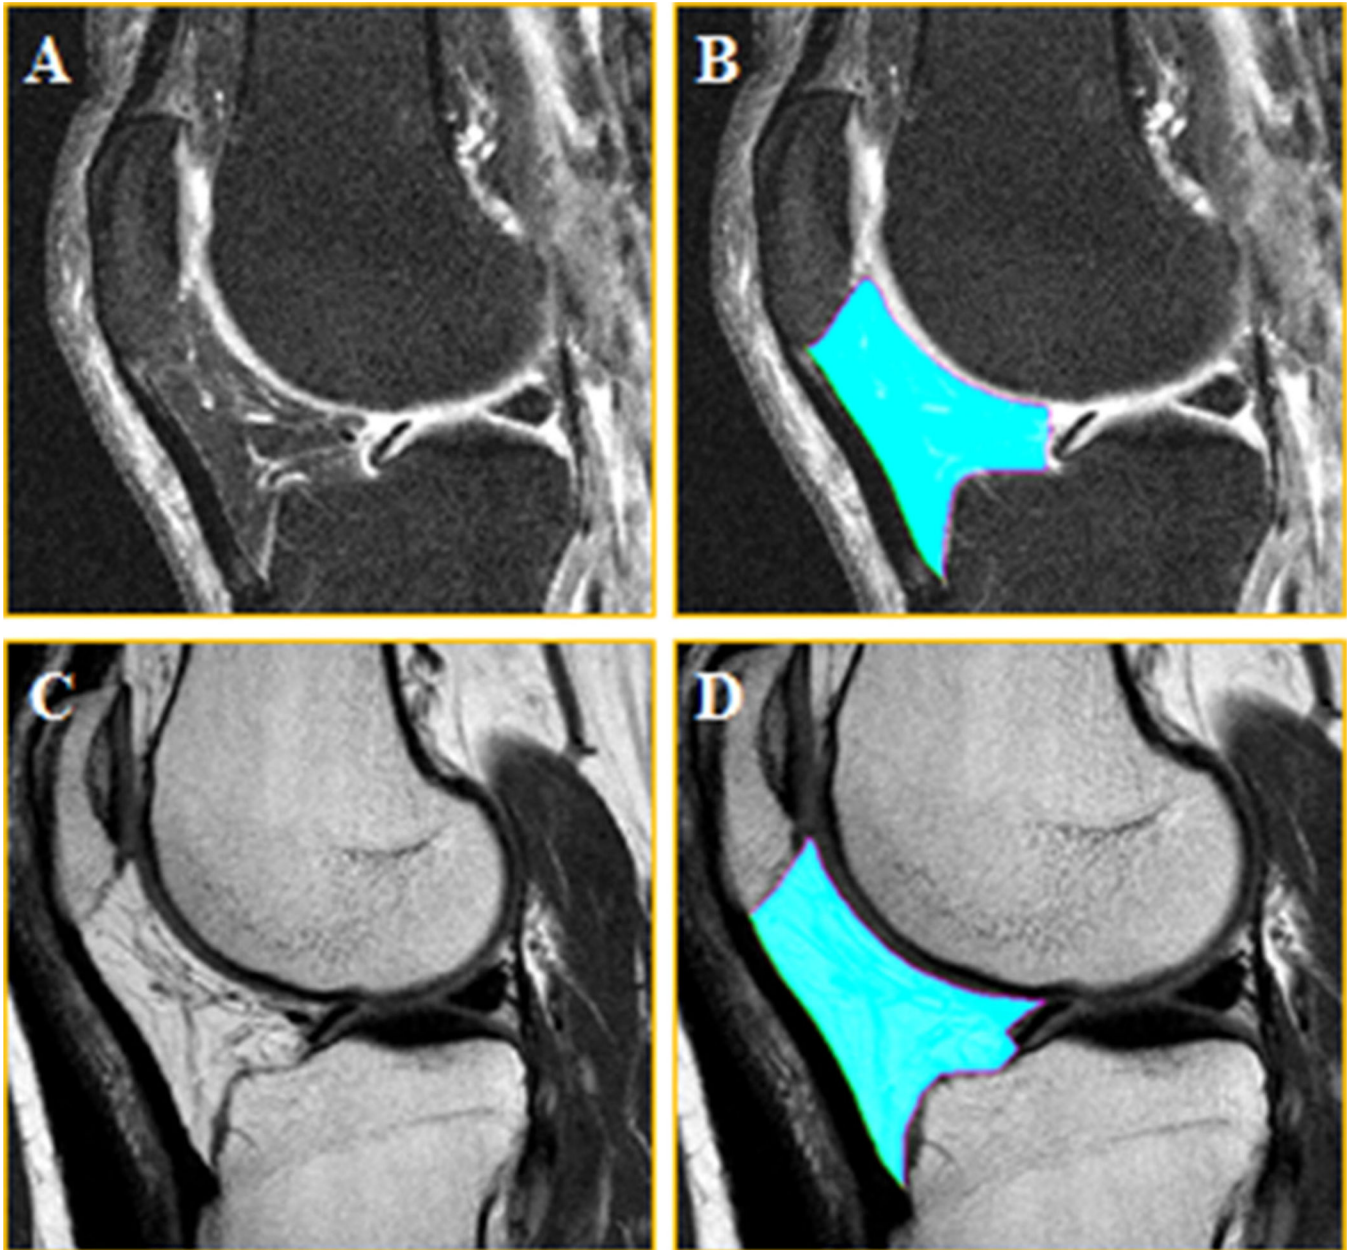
Intermediate-weighted fat-suppressed and non-fat-suppressed sagittal MR images of the infra-patellar fat pad (IPFP)
